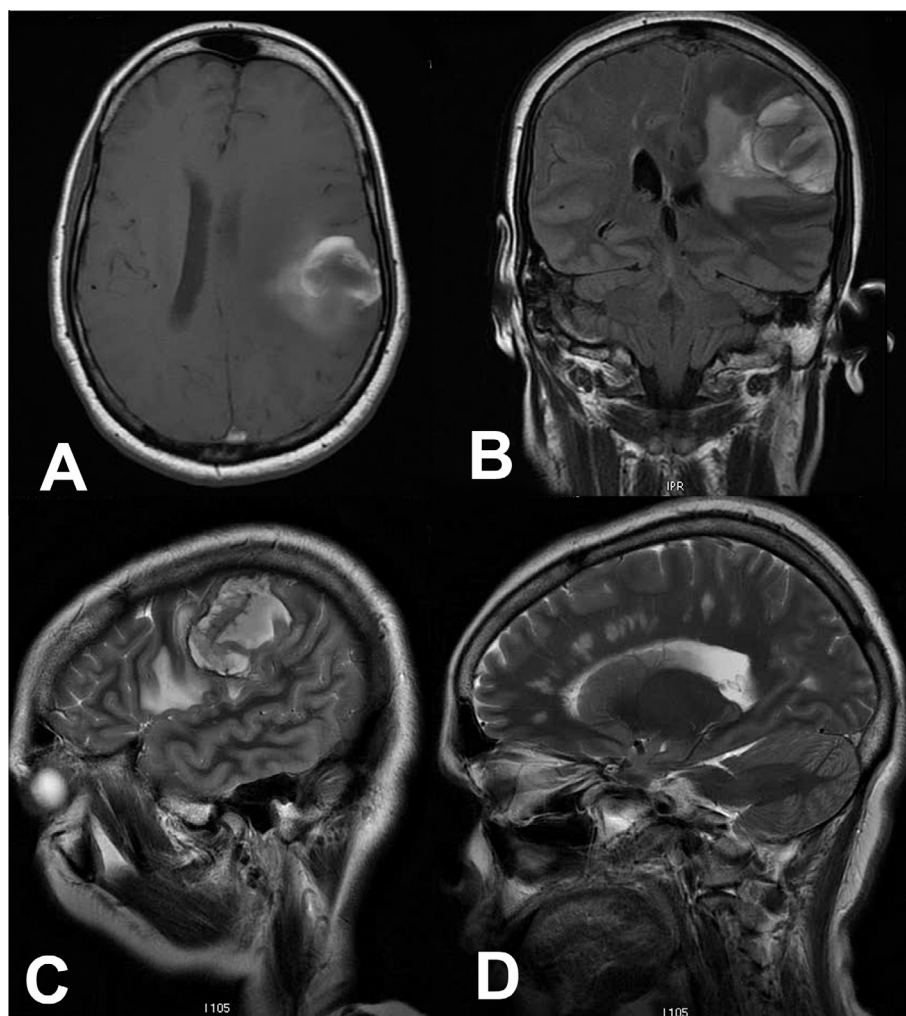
Axial T2 weighted MR image showing large heterogenous predominantly hyperintense left parietal lobe lesion showing hypointense hemosiderin rim, perilesional extensive vasogenic edema and mild midline shift to right. Also note the periventricular perpendicular hyperintense lesions in right frontal lobe suggestive of demyelination foci.
